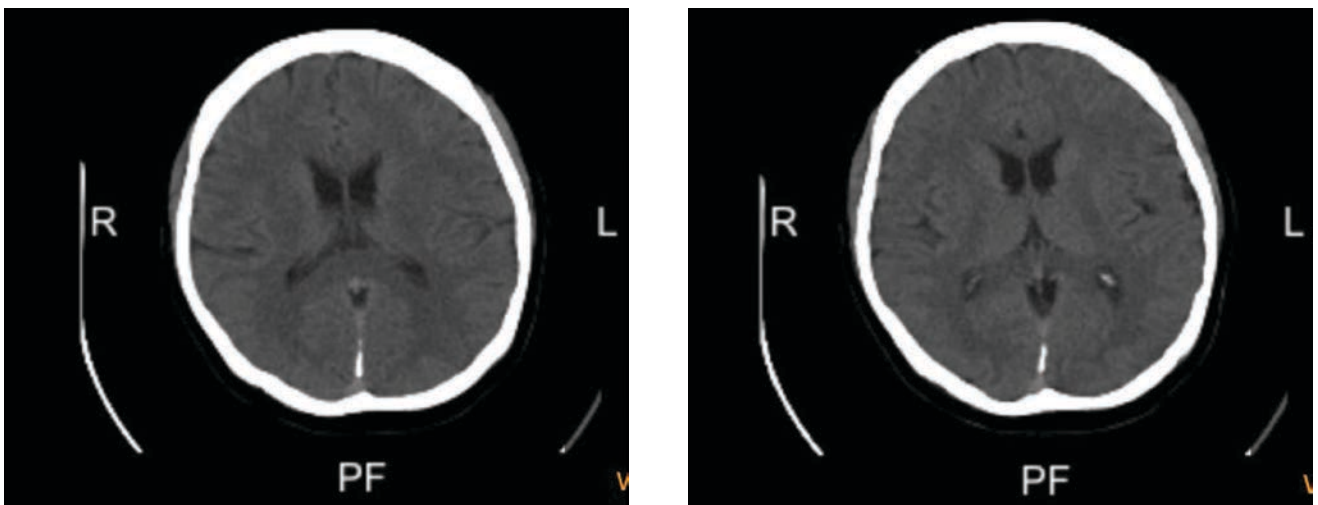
The brain CT scan of the patient ruled out brain metastases
